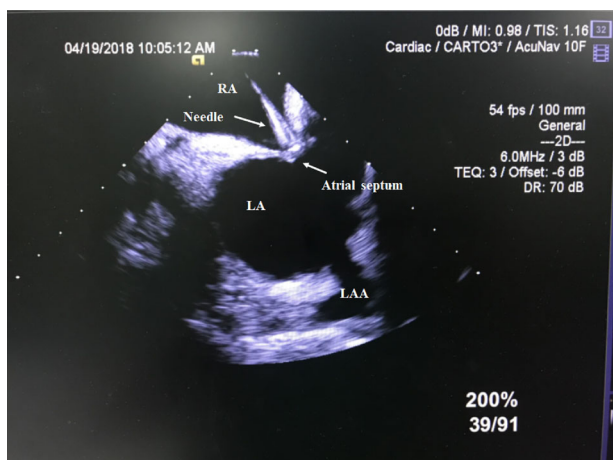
Trans-septal puncture under the guidance of ICE. ICE, intracardiac echocardiography; LA, left atrium; LAA, left atrial appendage; RA, right atrium [Color figure can be viewed at wileyonlinelibrary.com]
